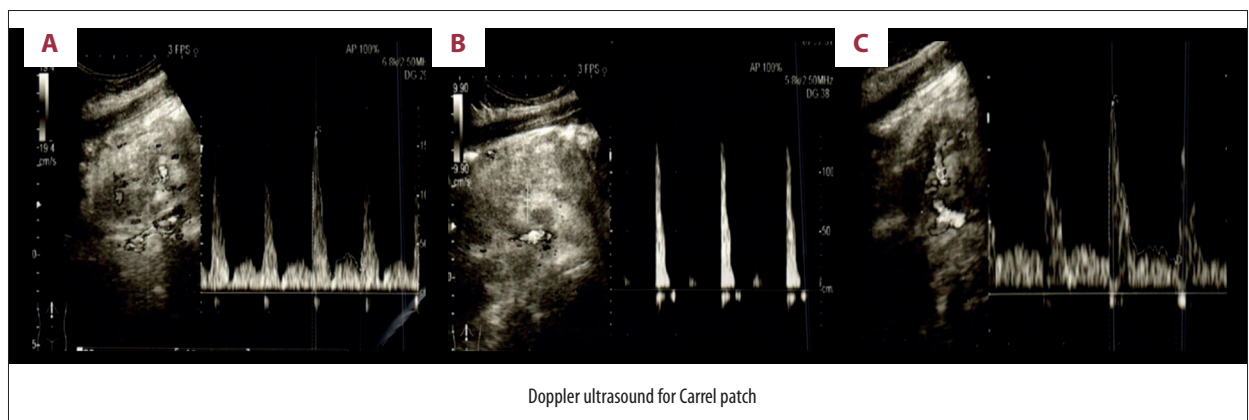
Doppler ultrasound images acquired at the Carrel patch in the pancreas graft before, during, and after thrombosis. The wave pattern on the right of each panel indicates the arterial blood flow measured (A) before thrombosis detection and at 6 days after the simultaneous pancreas-kidney transplantation; (B) at the time the thrombus was detected; and (C) at a time after complete thrombolysis. Panel B shows how the wave shape changed; the gentle slope with 2 phases changed into a single spike wave.
